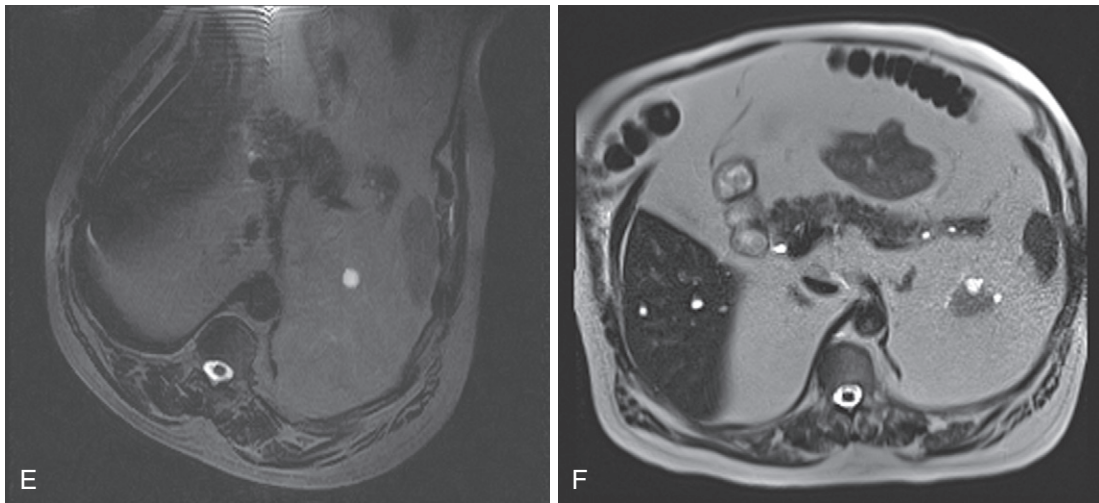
cont'd Axial T2-weighted image obtained on a different patient on a 0.3-Tesla system (E) demonstrates prohibitive artifact distorting the image beyond diagnostic utility compared with the corresponding image (F) from a follow-up study performed on a 1.5-Tesla short-bore, open-configuration system.
